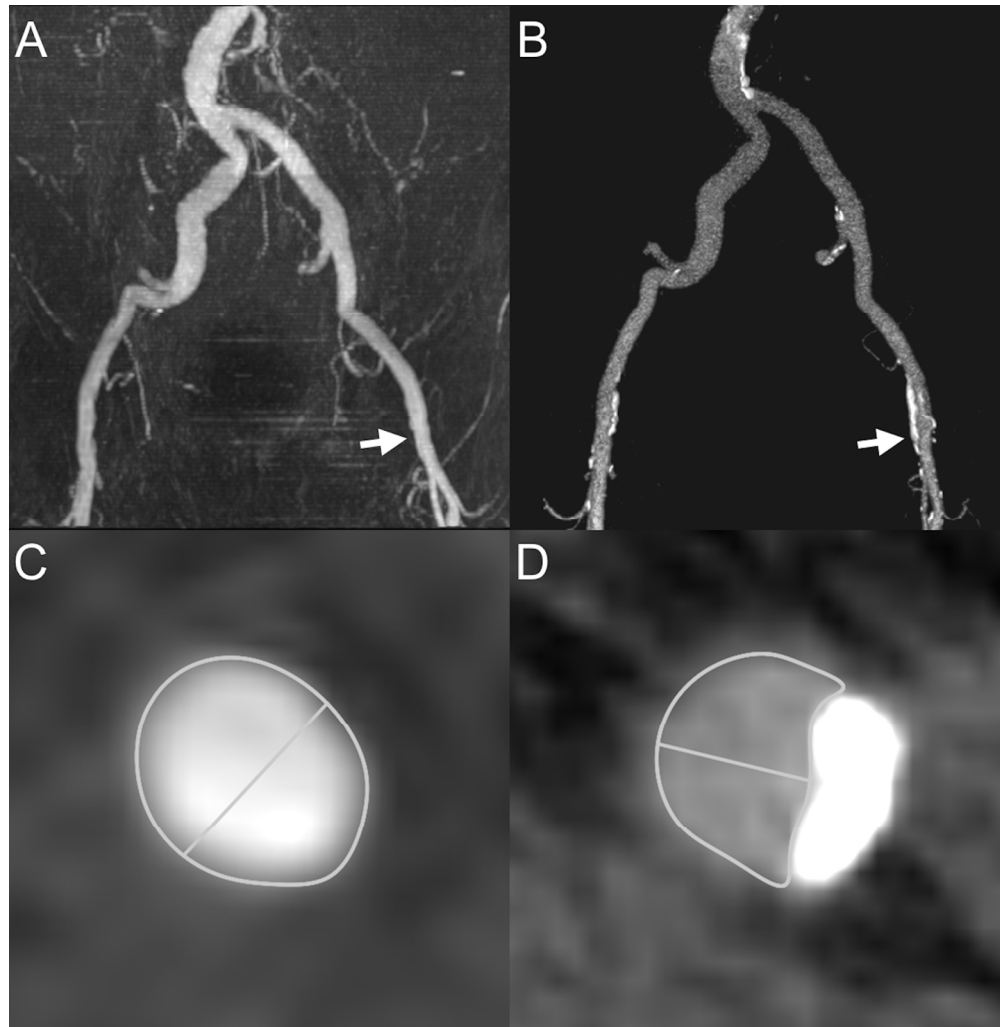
Case Example. Volume-rendered images of the ileofemoral artery are demonstrated using MRA (a) and CTA (b). Using a threshold of 7 mm, this represents the single case in which MRA (c) reported an adequate minimal diameter (7.1 mm) and CTA (d) did not (6.8 mm) in the left femoral artery (arrows). Significant calcium and blooming artifact is present on CTA, which may explain this difference. Lines and traces on the short-axis images represent the minimal diameter and area, respectively. CTA, computed tomographic angiography; MRA, magnetic resonance angiography.
